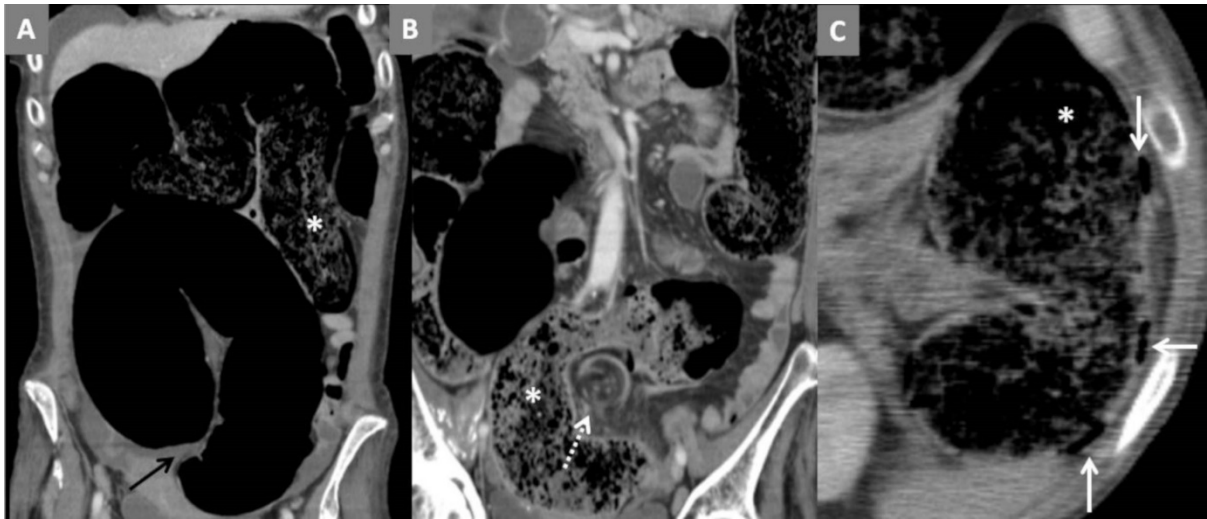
Computed Tomography: The distended sigmoid colon with the classic "coffee bean sign" configuration of sigmoid volvulus due to its juxtaposed walls (black arrow). There are two points of abrupt reduction with the torsion of the intestinal loop and the adjacent mesentery ("whirl sign"- dashed white arrows), determining marked distension of the upstream colic segments, with gaseous and fecal content (asterisks). Multiple gas-filled cysts in the submucosa of the bowel walls (foci of pneumatosis) in the descending colon are identified (white arrows).
